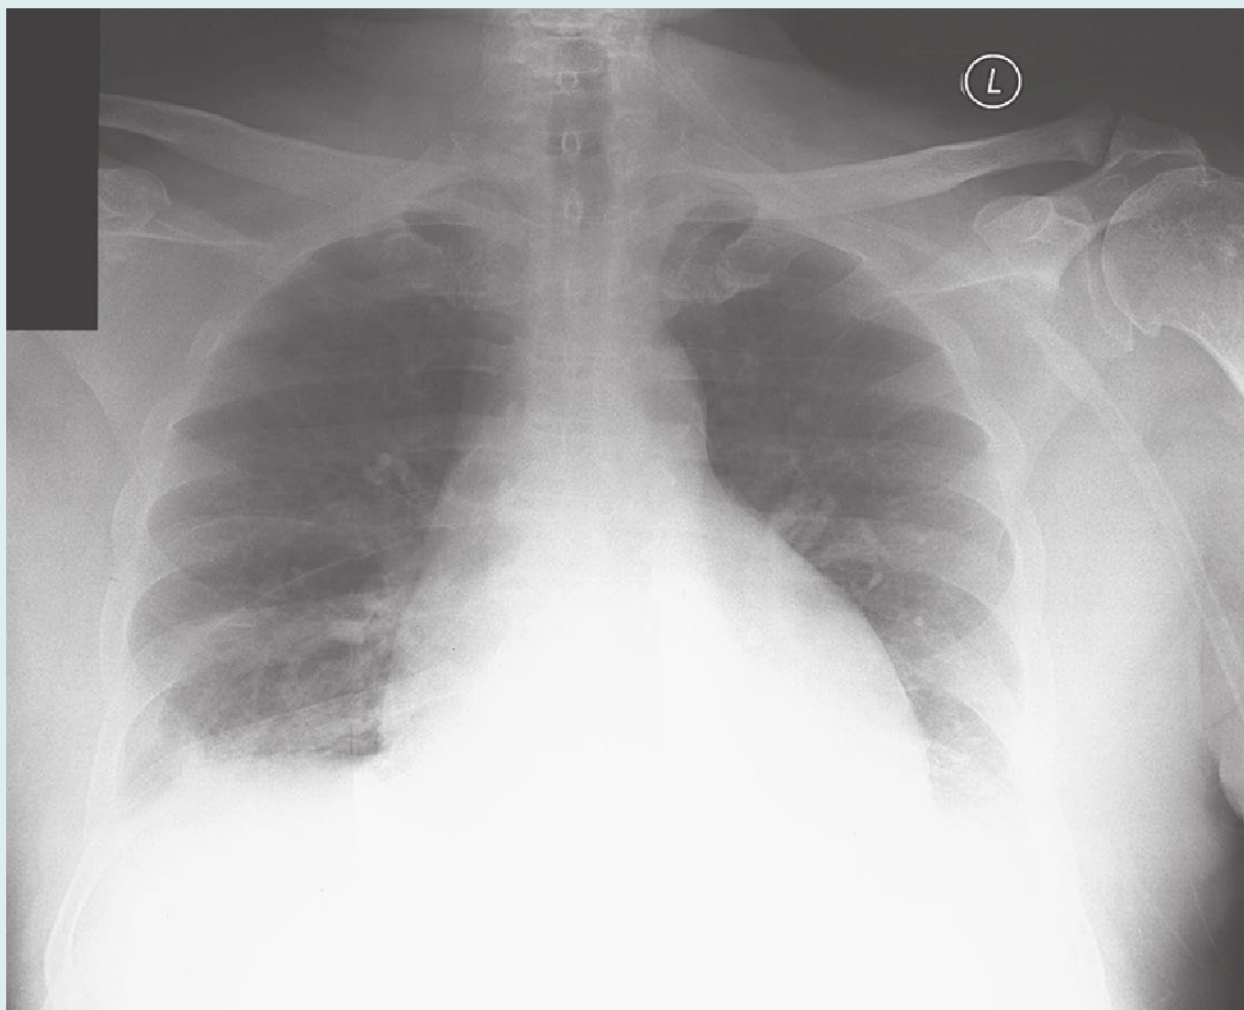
Chest x-ray. (Courtesy of Dr. Jorge Albin.)
